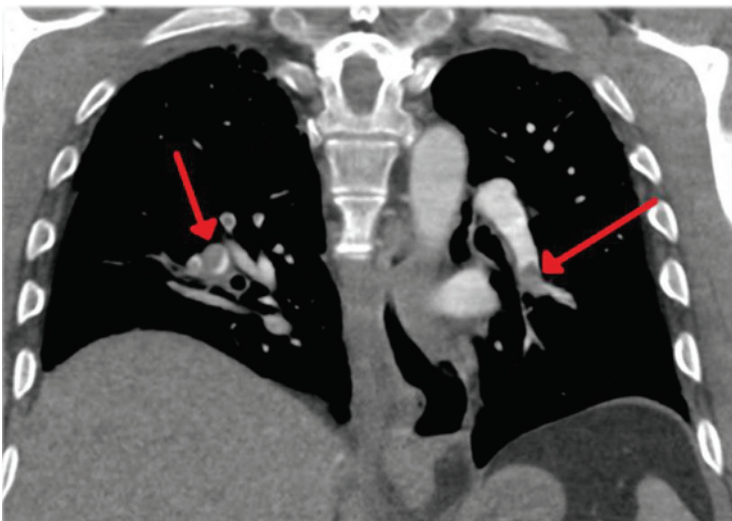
Computed tomography scan of the chest showing bilateral pulmonary emboli. (With thanks to Dr Richard Dillon, London.)
